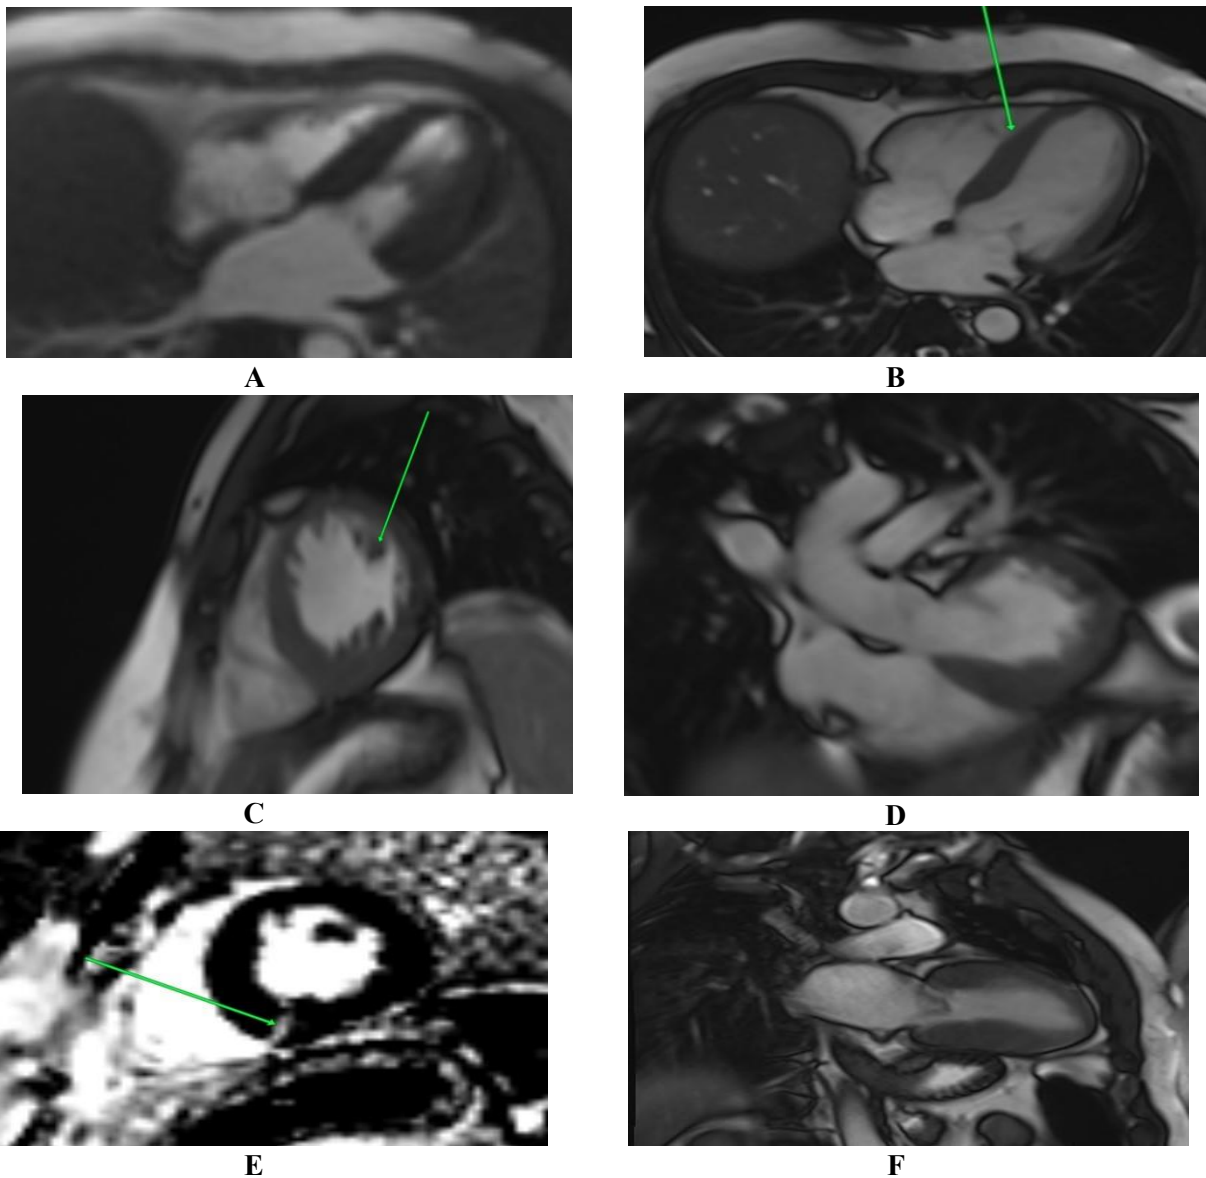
A Male patient, 34 years old, hypertrophic cardiomyopathy by echocardiography.
